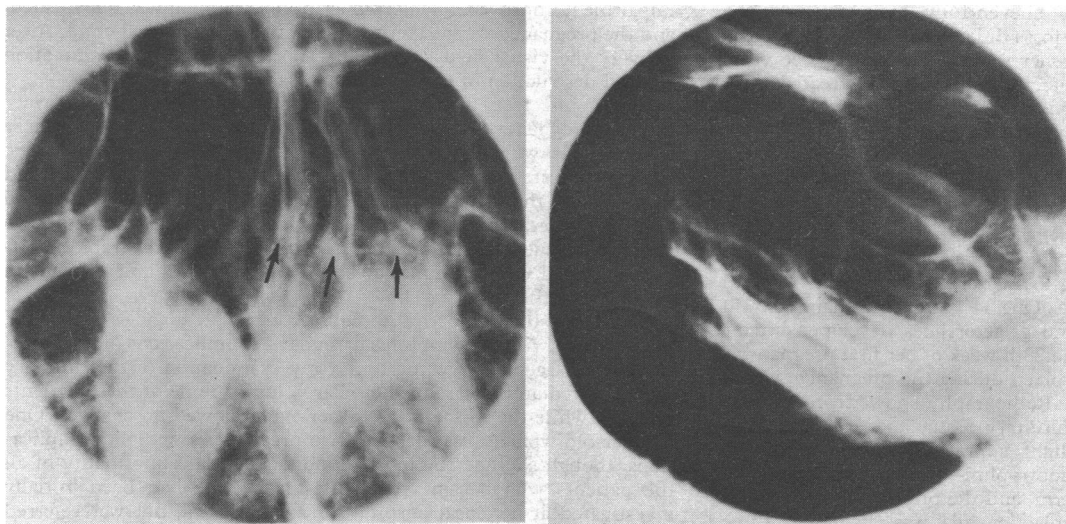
Case 11. Frontal (left) and lateral (right) x-ray pictures showing pronounced asymmetry and enlargement of pituitary fossa (arrowed) in a 31-year-old hyperprolactinaemic woman with eight years of amenorrhoea and galactorrhoea who had two uneventful bromocriptine-induced pregnancies.
